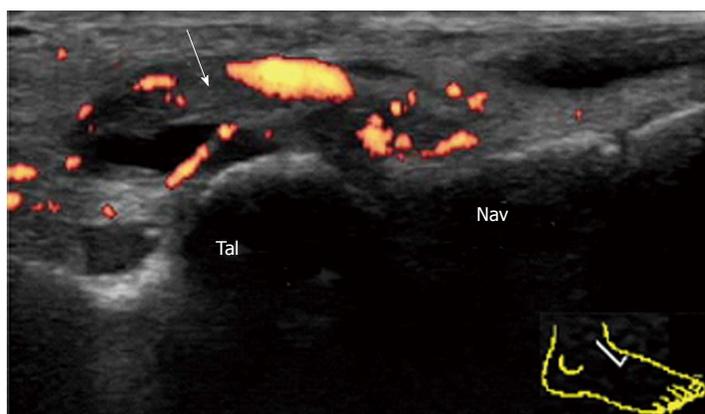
Synovitis of the talonavicular joint in psoriatic arthritis. Longitudinal power Doppler sonogram of the dorsal aspect of the TNJ shows synovial effusion and marked synovial thickening (arrow) with peripheral vascularization. TNJ: Talonavicular joint; Tal: Talus; Nav: navicular.
